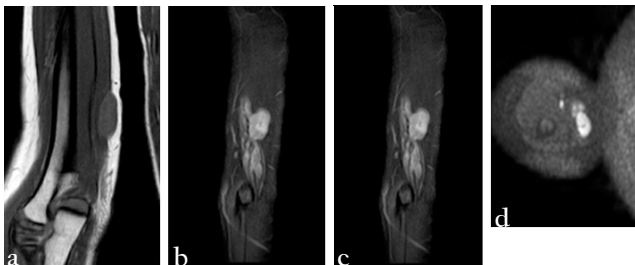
(a) Coronal T1WI shows well margined ovoid lesion along the course of ulnar nerve proximal and lateral to olecranon. The lesion displays isointensity signal in T1WI and intermediate to hyperintensity signal in T2WI. (b) Nerve thickening and edema is seen in segment of Ulnar nerve proximal and distal to the lesions in coronal STIR section. (c) The lesion shows bright signal in axial STIR. (d) Axial DWI shows diffusion restriction in the lesion and focal areas of thickened nerve.
